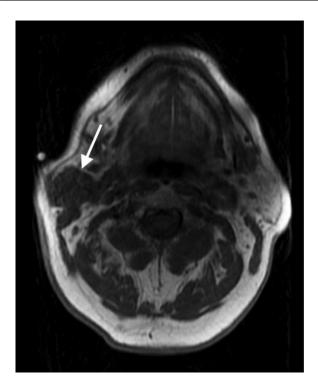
T1 axial image of the initial MRI examination which revealed a hypointense mass in the right parotid gland (arrow).
